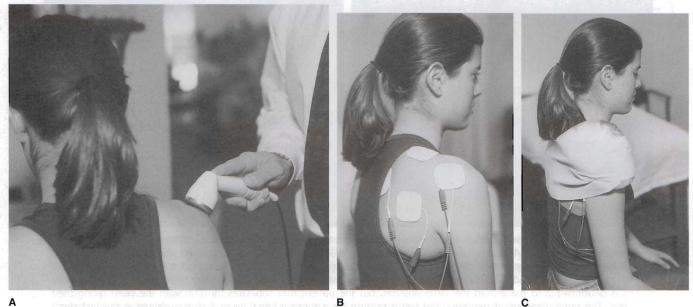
Modalities for pain relief. A, Ultrasound. B, Galvanic stimulation. C, Cryotherapy.
